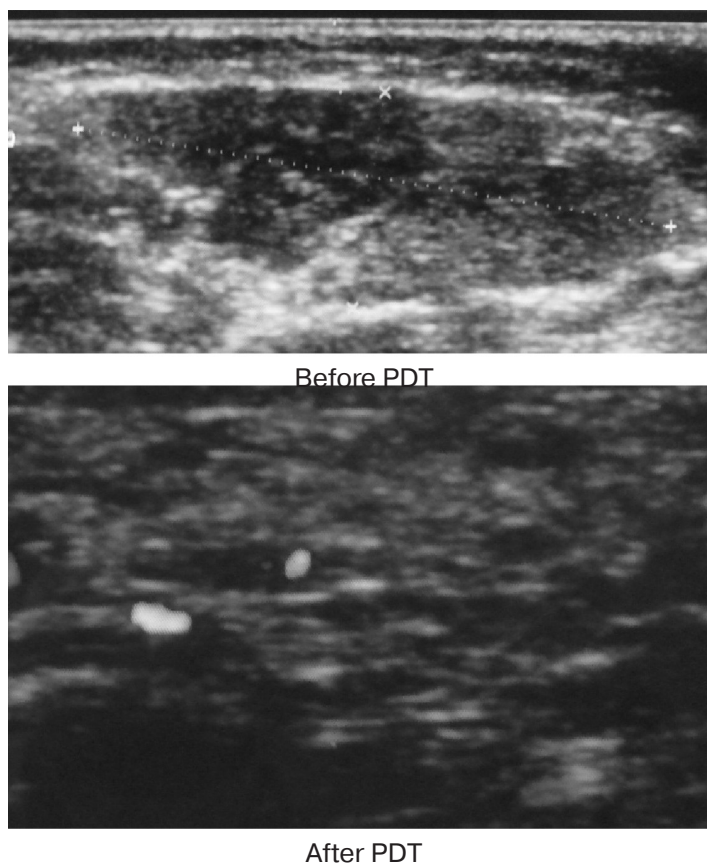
Doppler ultrasound evaluation reported good response to the therapy
